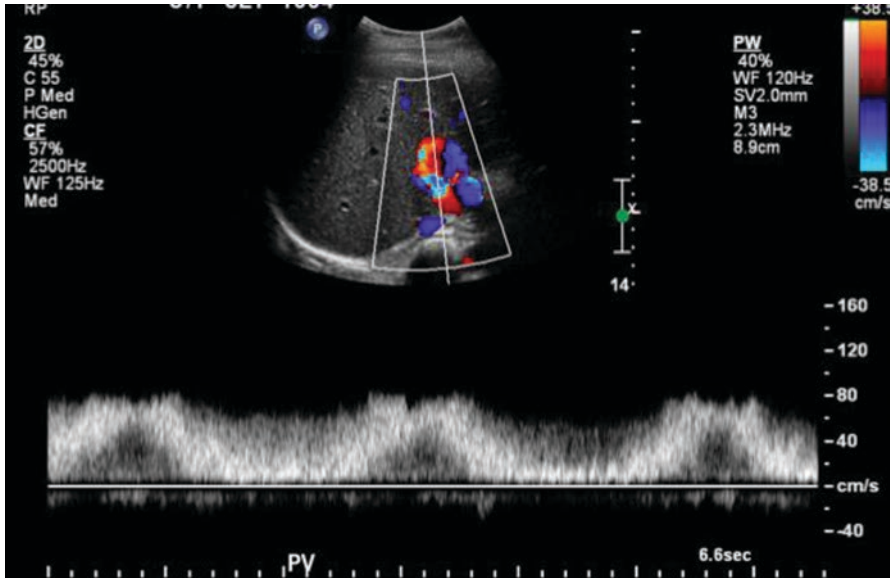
Portal vein stenosis after liver transplant; spectral Doppler shows high-velocity, turbulent flow on postoperative day 5
